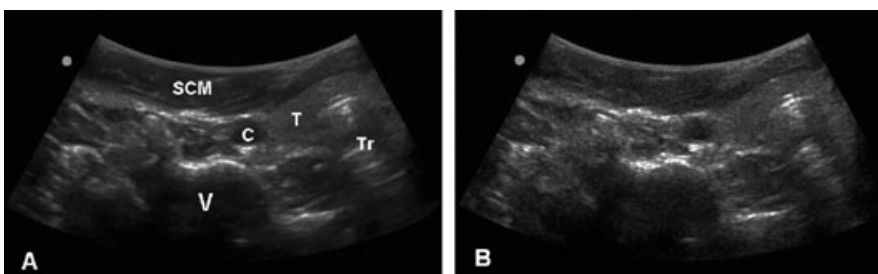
Ultrasonography of neck: (A) Multiple-beam mode enabled. (B) Multiple-beam mode disabled. V, vertebra; SCM, sternocleidomastoid muscle; C, carotid artery; T, thyroid; Tr, trachea.
